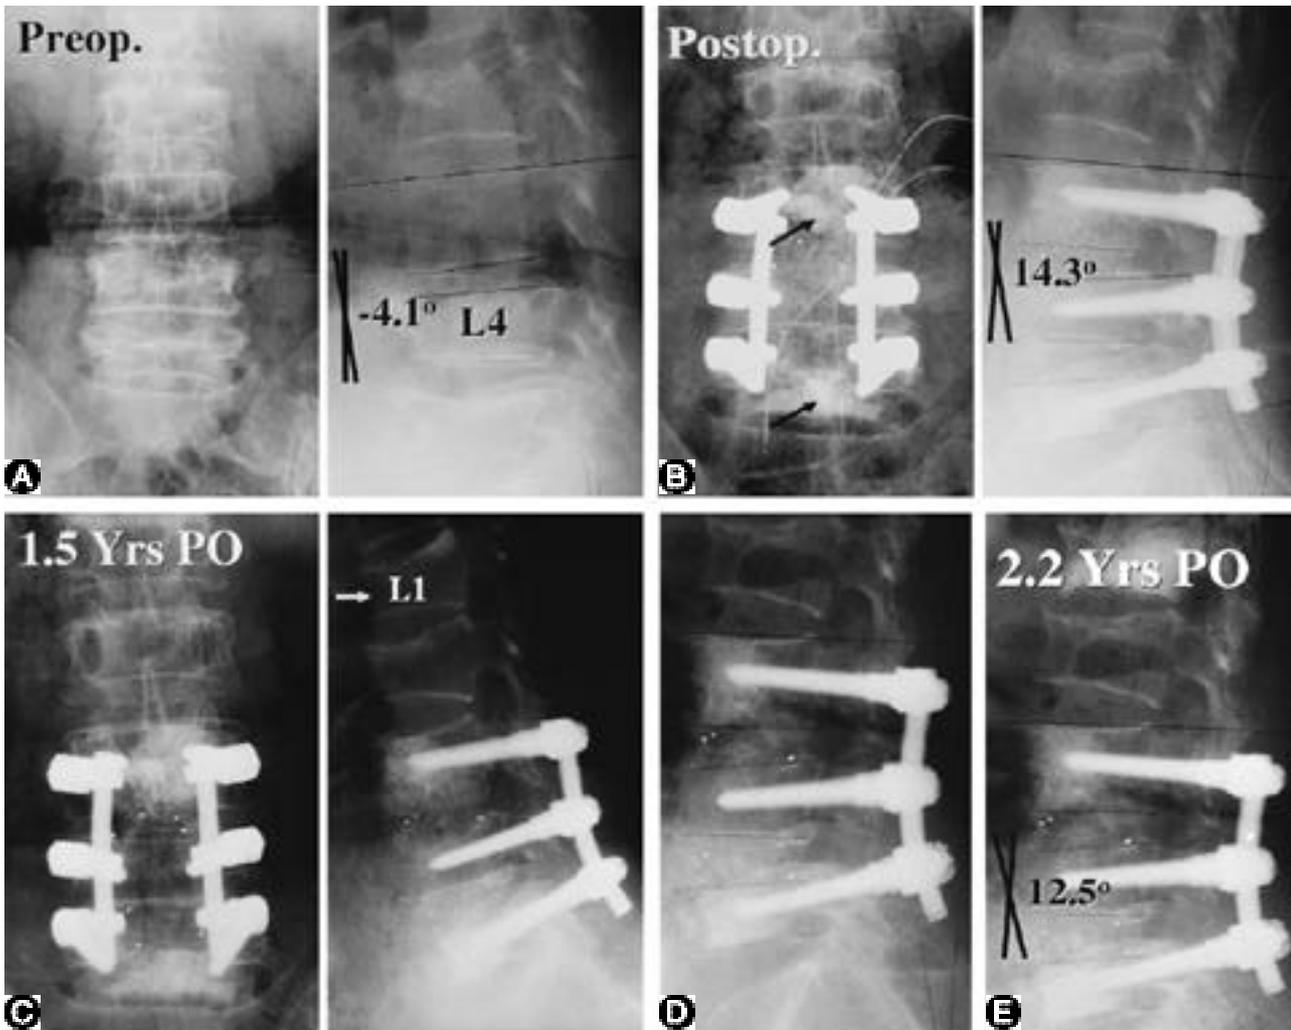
A 66-year-old female with spinal stenosis at L3-4-5 associated with compression fracture of L4 and L5 bodies. Preoperative AP and lateral radiographs show Jikei grade II/III osteoporosis with -4.1° of local L3 to L5 kyphosis (A). Postoperative radiographs after L3-4-5 cage-PLIF and PMMA augmentation for Rt L3 and L5 screws (black arrows) show satisfactory correction of L3 to L5 sagittal angle to 14.3° (B). The 1.5-year follow-up examination shows L1 compression fracture (white arrow) from slipped down accident (C). Two weeks after fracture we performed percutaneous L1-vertebroplasty (D), and 2.2-year follow-up radiograph shows only a minor loss of the correction and no device-related problems (E).
